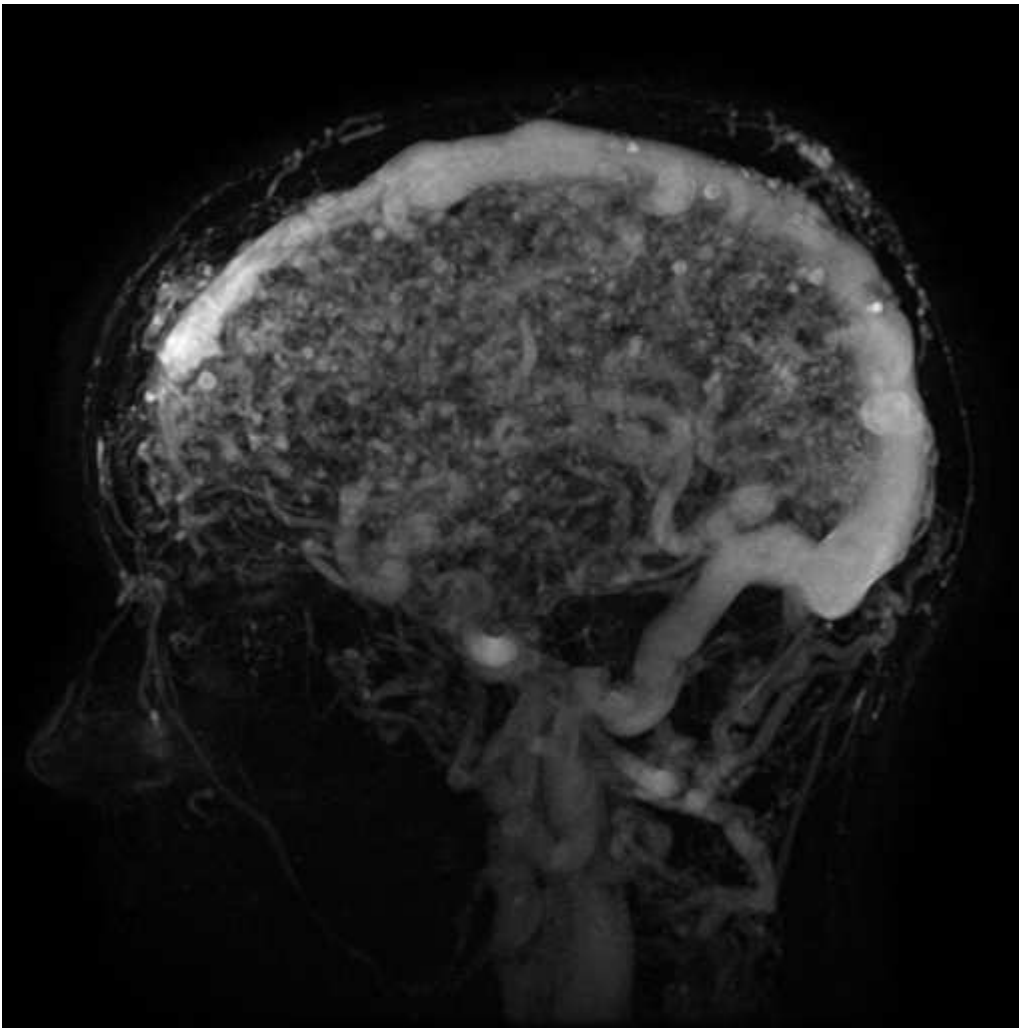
MRI TRICKS sequence of the same AVM.
